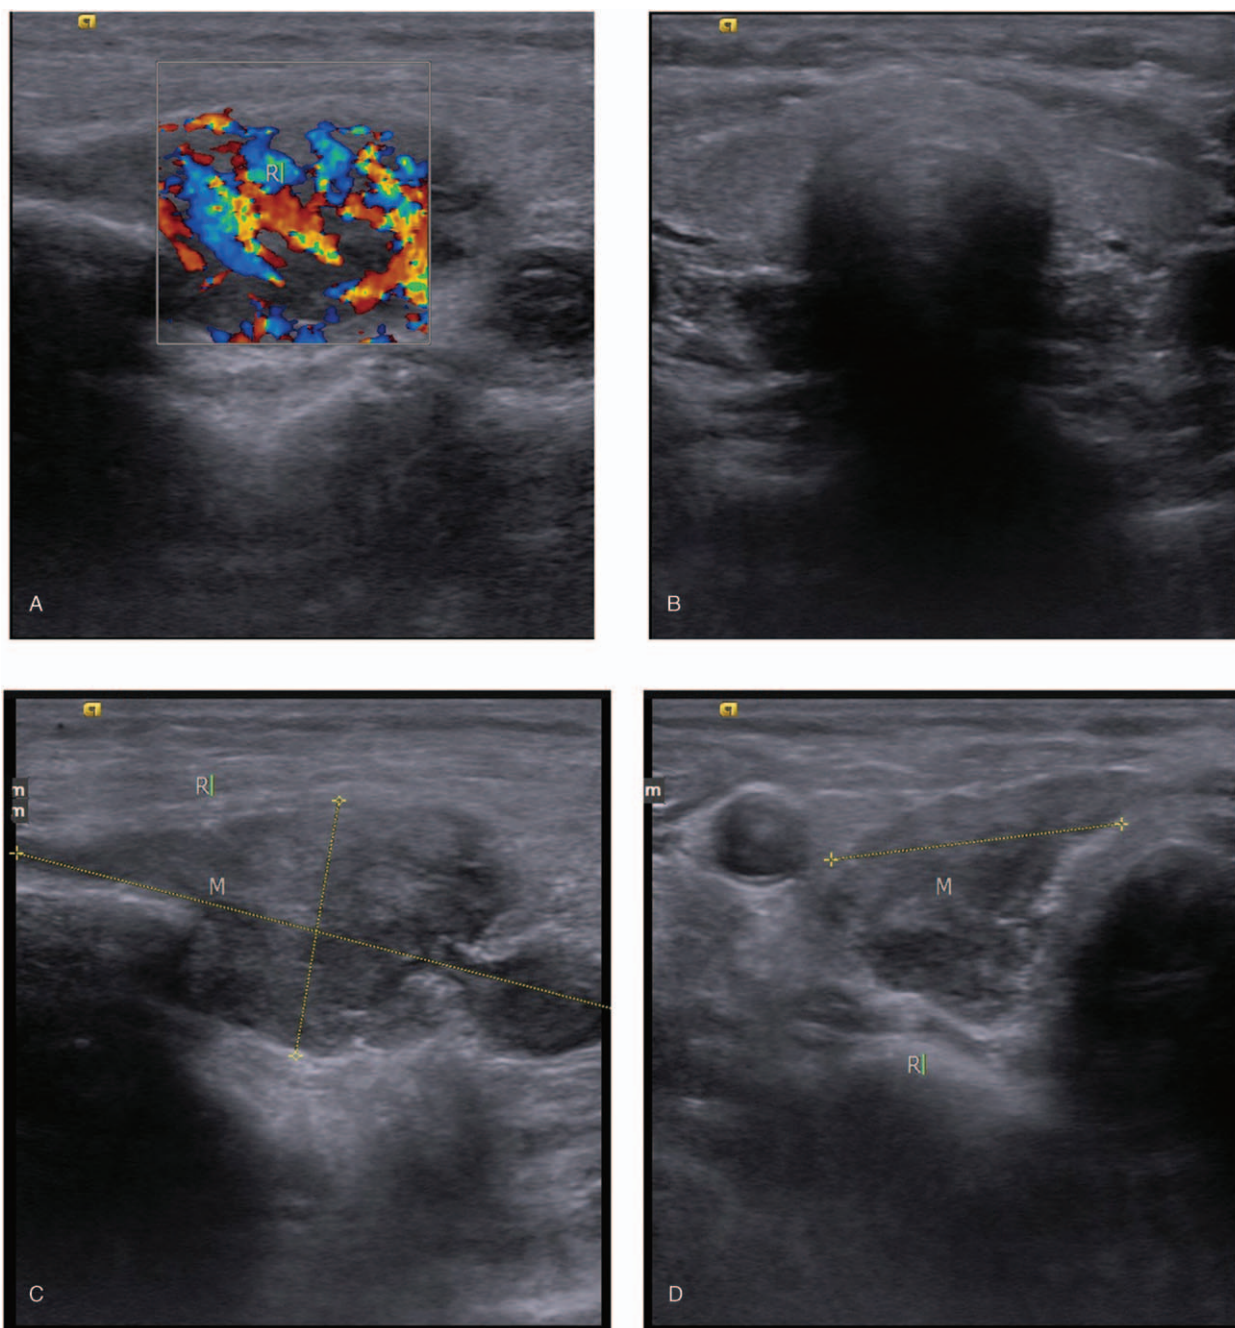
Preoperative color Doppler. (A–D) The hypoechoic mass between the posterior side of the right thyroid lobe and the carotid artery, and rich blood flow signals could be identified within the mass from different orientations.
